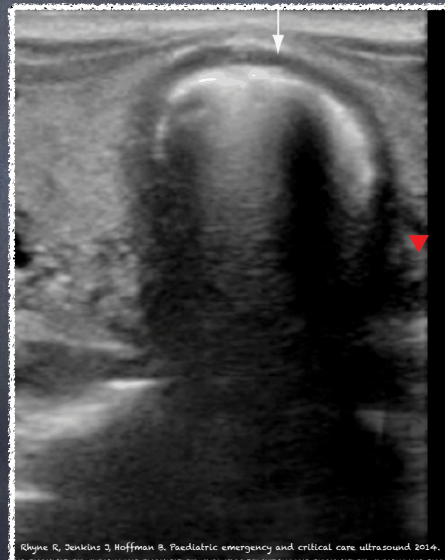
Dunbar J Hoffman R. Pediatric emergency and critical care ultrasound 2014.
